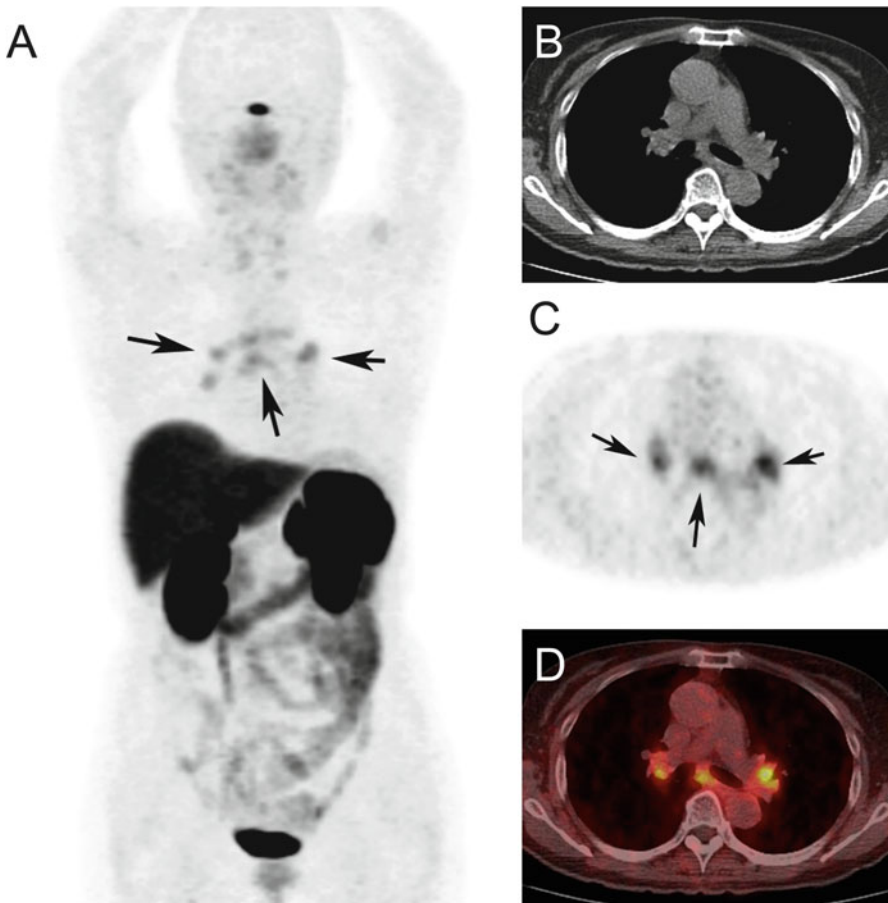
A 65-year-old woman with suspected sarcoidosis. A maximum intensity projection image (a) and axial CT (b), DOTATOC PET (c), and fused (d) images are shown. Moderate to intense uptake of DOTATOC is observed in hilar and mediastinal lymph nodes (arrows)
